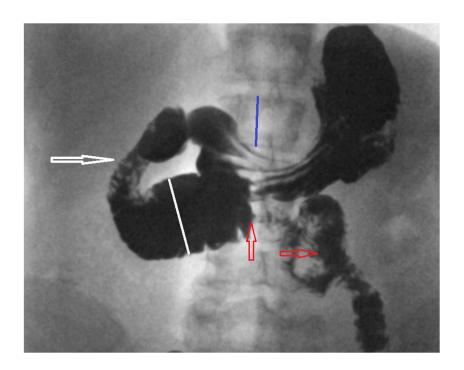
Rotated x-ray from article by Kirby et al. True height L-1 (blue line) is 2.2 cm. The stomach is not dilated. The width of the duodenum (white line) between the Kapanji sphincter (white arrow) and the Ochsner sphincter (between the red arrows 3.5 cm long) is 3.7 cm. Evacuation of barium into the jejunum began.
